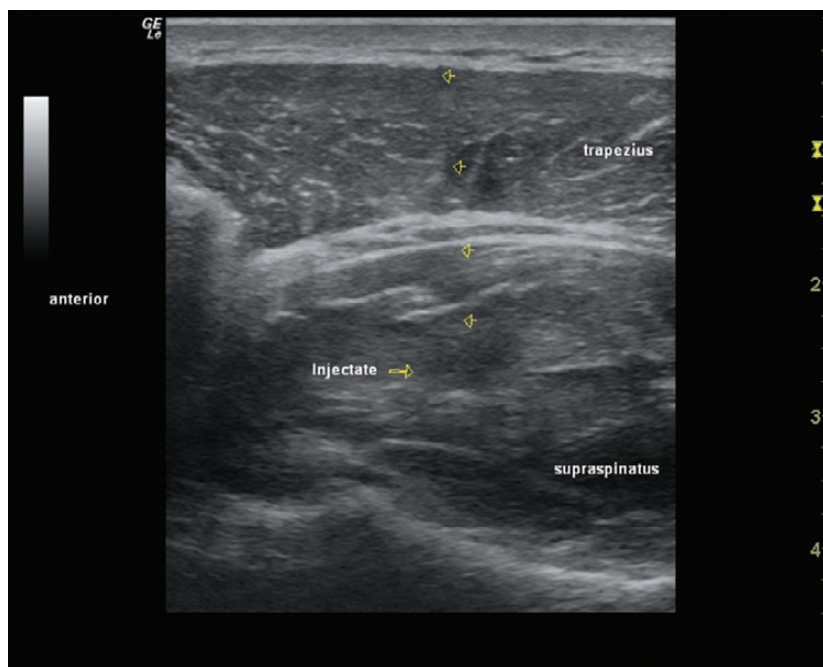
Ultrasound image of out-of-plane injection of local anesthetic into the supraspinatus trigger point. The arrowheads point to the needle.
